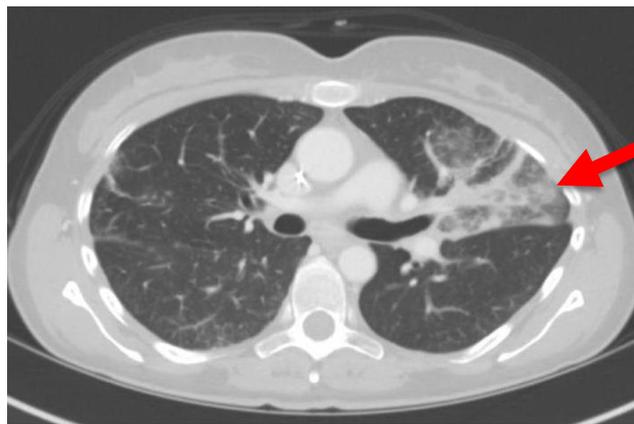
CT image showing lymphangitic spread of SRCC in the lung (red arrow)
